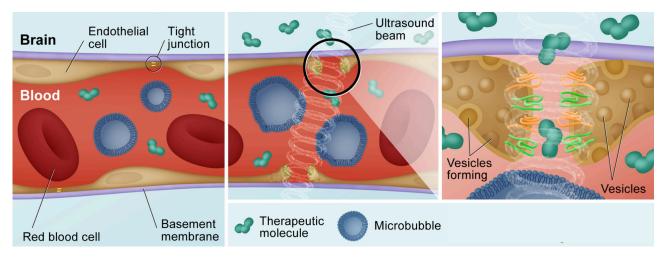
(Yetman, 2023): Ultrasound beam microbubbles prying open the blood-brain barrier
